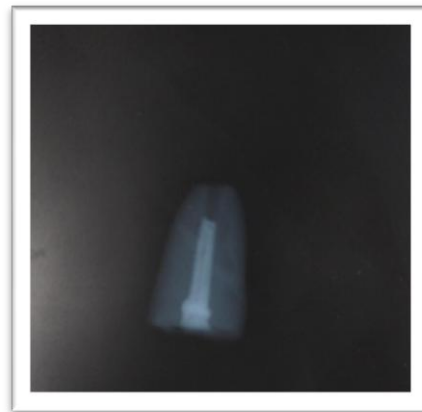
Radiographic picture of root end cavity
